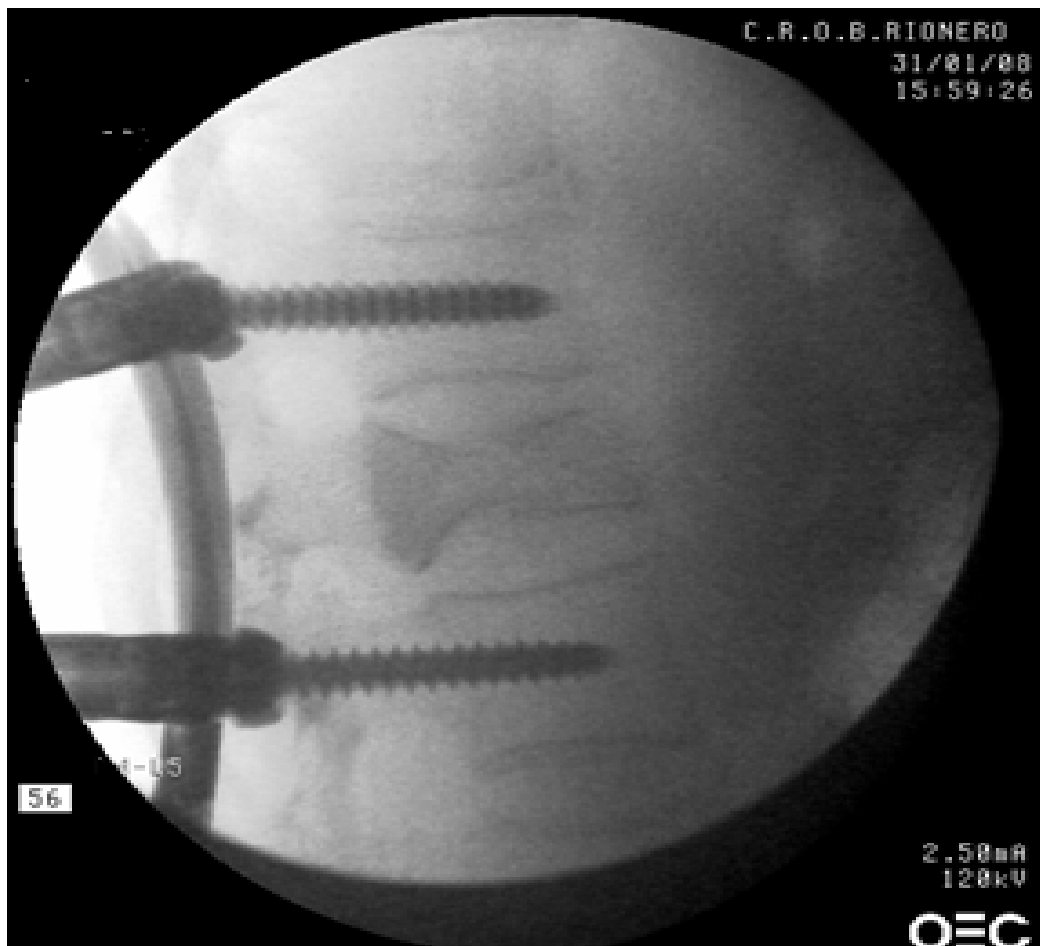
LL X-ray image of percutaneous screw assisted spinal stabilization device
